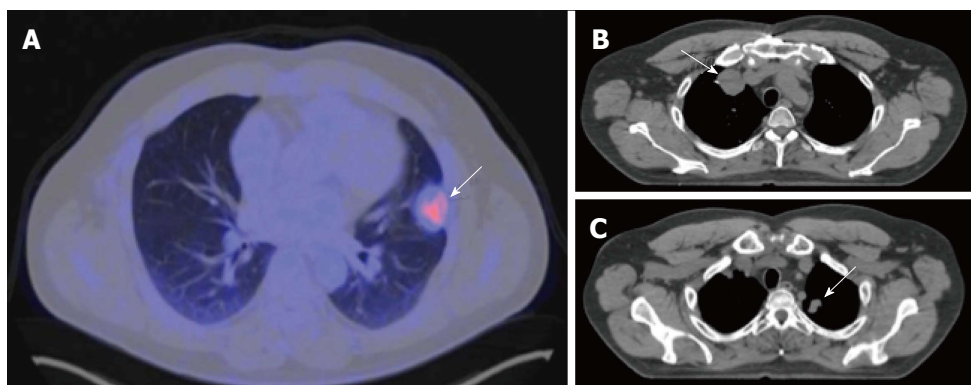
Positron emission tomography-computed tomography, three months later. A: Subpleural hypermetabolic nodular lesion in left upper lobe (SUV max 3.8) measuring 27 mm × 30 mm, suggestive of tumor activity; B and C: Computed tomography, a 38-mm nodule in right upper lobe and another 20-mm nodule in left upper lobe, compatible with metastasis.
